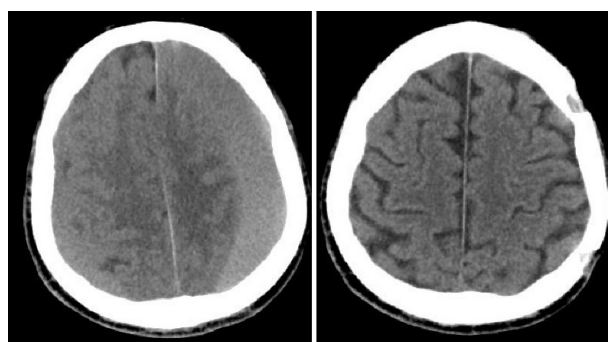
In a case with a preoperative Karnofsky's score of 70, postoperative dysphasia and a lower Karnofsky's score (40) were encountered, although parenchymal expansion was fully developed in the postoperative CT examination
